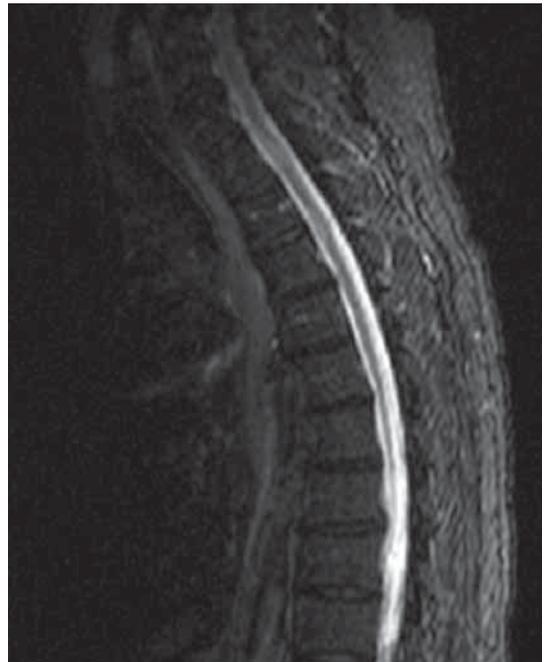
Cervical and thoracic spine MRI: sagittal sections T2
